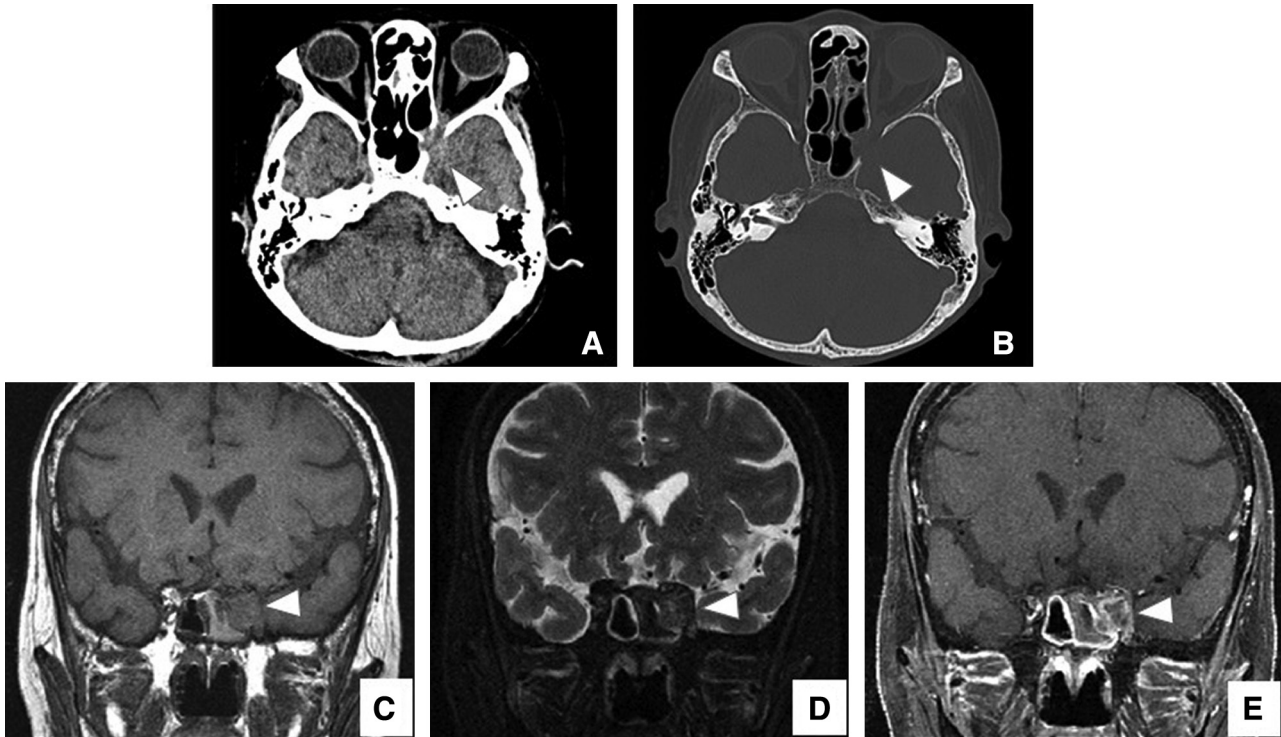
CT demonstrated that erosion of the lateral wall of the left sphenoid sinus with extension to the orbit (A, B). The MRI showed an isosignal intensity on the T1-weighted image (C) and a low signal on the T2-weighted image in the left sphenoid sinus (D). The expansile lesion is seen in the sinus with abnormal enhancement (E). CT: computed tomography, MRI: magnetic resonance imaging.
